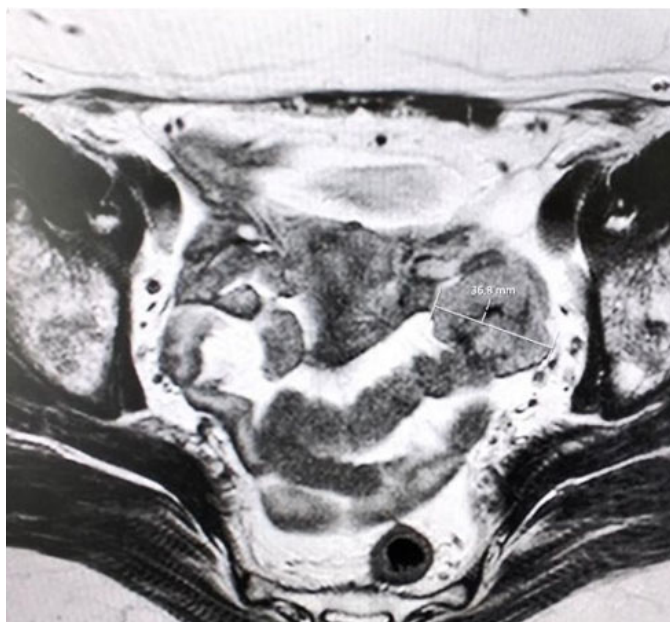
Pelvic magnetic resonance imaging showing a solid mass of 36 mm without evidence of distant involvement.
